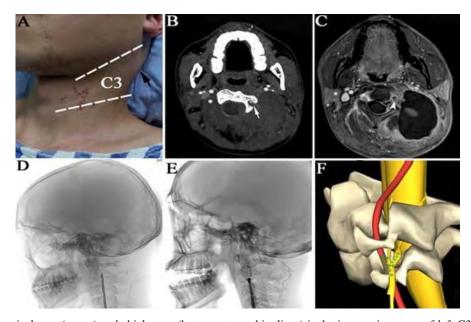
A. The area of cervical mass(arrow) and chickenpox(between two white lines) is the innervating areas of left C3 nerve posterior root; B. Enhanced CT performed contrast media display a weak signal in the artery upon the level of C4 and a mixed signals of soft tissue density images which size is about 3.3×4.4cm(arrow); C. MRA indicated that there was hemorrhage in the cervical mass adjacent to the vertebral artery; D,E. Angiography showed left vertebral artery dissection rupture with pseudoaneurysm formation; F, the local relation of the vertebral arteries and the left C3 nerve root.
